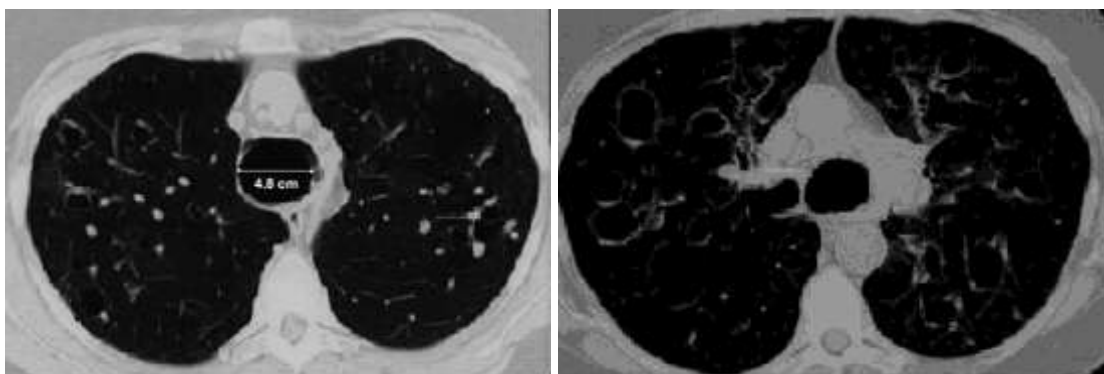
CT scan showing increased diameter of trachea and main bronchi with transversal diameters of the trachea of 4.8 cm, while right and left main bronchi had diameter of 2.9 cm and 2.8 cm respectively, with ground glass opacification and multiple bilateral nodules and cystic bronchiectatic changes noted bilaterally.
